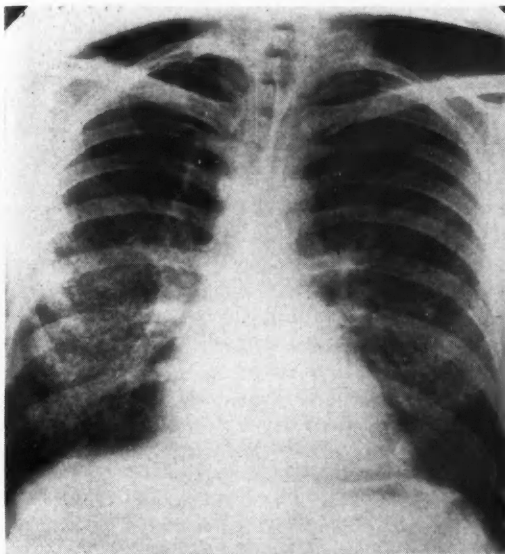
X-ray evidence of extensive hemosiderosis with normal pulmonary artery pressure (proved at operation).
